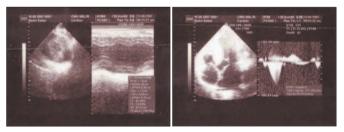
2D and M-mode echocardiography showing marked thickening of interventricular septum.
